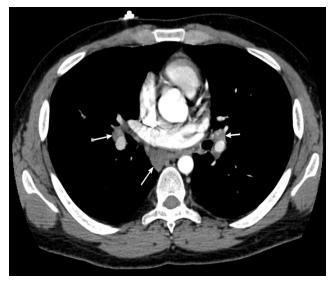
CT chest with contrast showing bilateral hilar lymphadenopathy (arrows).
